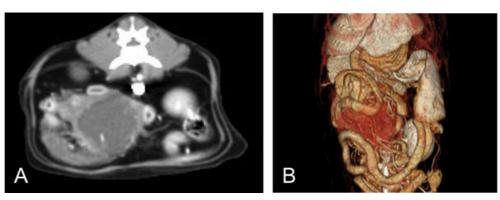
Abdominal transverse image on CT (A) and 3D reconstructed image (B). (A) A large mass with soft tissue attenuation was seen medial to both kidneys and the capsule of the mass was enhanced after contrast administration. (B) The small intestine was displaced around the mass and its direction was difficult to determine.
